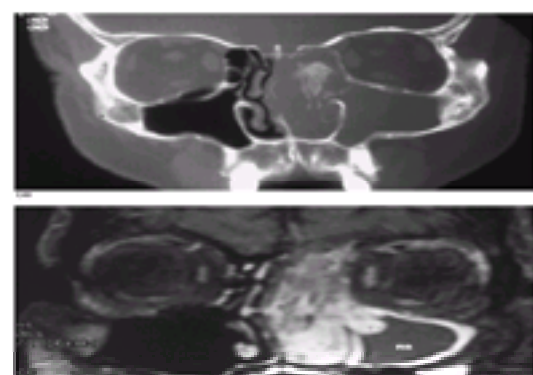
Inverted papilloma. (a) CT demonstrates opacification of the maxillary sinus. (b) MRI (T_1 -weighted contrast-enhanced with fat suppression applied) better delineates the extent of the tumor, differentiating between the retained secretions (RS) and the more brightly enhancing tumor (asterisk) at the maxillary ostium. (Images generously provided by David M. Yousem, M.D.)
